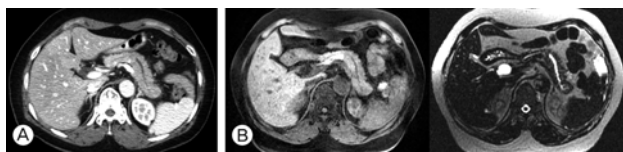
(A) Finding of abdomen-pelvis CT, (B) Finding of MR pancreas.
